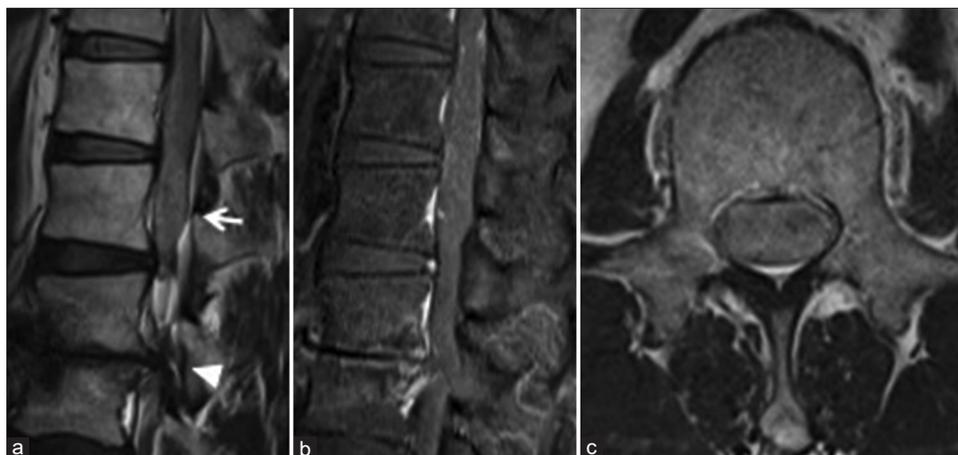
T2-weighted sagittal (a) and axial (c) images of the lumbar spine show a hyperintense intradural mass at L1 (arrow) and severe lumbar canal stenosis due to the degenerative change at L2/3 (arrow head). Post contrast T1-weighted sagittal image (b) shows no enhancement in the mass.
